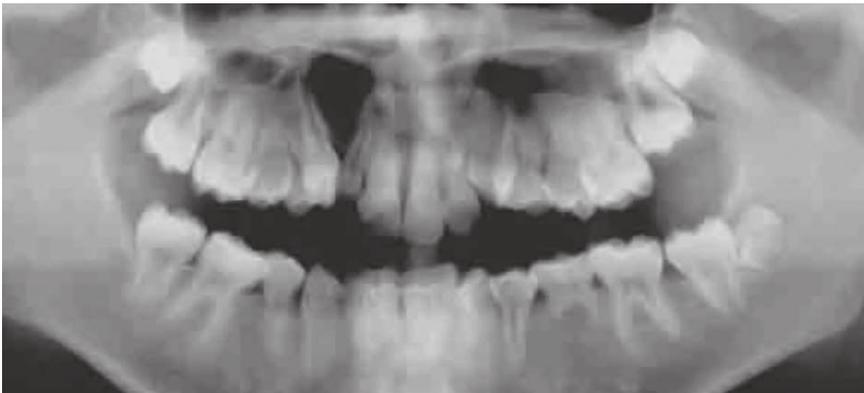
Initial radiographs.
